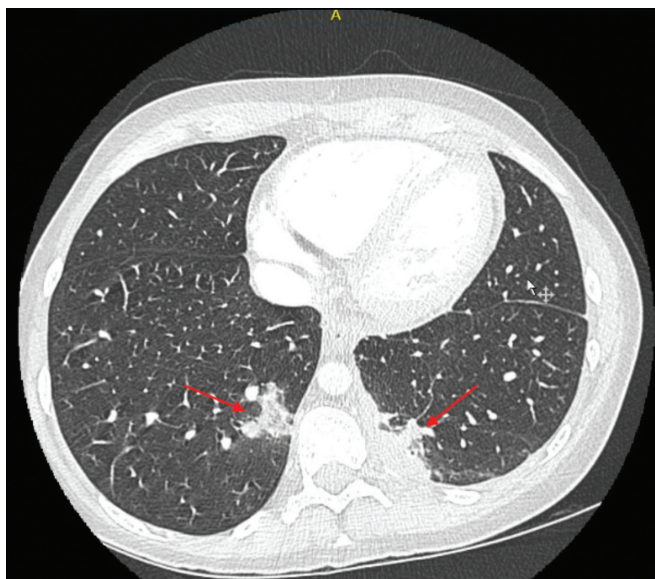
Axial contrast-enhanced computed tomography scan of the chest in a 31-year-old woman with fever and pleuritic chest pain 6 weeks after surgical abortion, showing bilateral subpleural lower lobe consolidation (red arrows), consistent with pulmonary infarction secondary to septic emboli.
